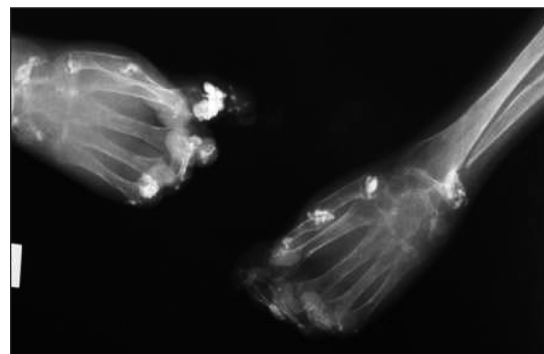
Radiograph of hand bones showing osteoporosis, flexion of fingers, joint ankylosis, acroosteolysis, soft tissue calcinosis.
